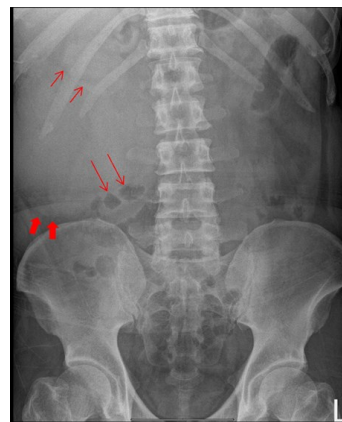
Abdominal radiograph showing a large right abdominal mass with its lower margin seen just above the right iliac crest level (solid arrows), displacing the bowel inferior and to the left (long arrows) and the right kidney to a more superior position (short arrows).
